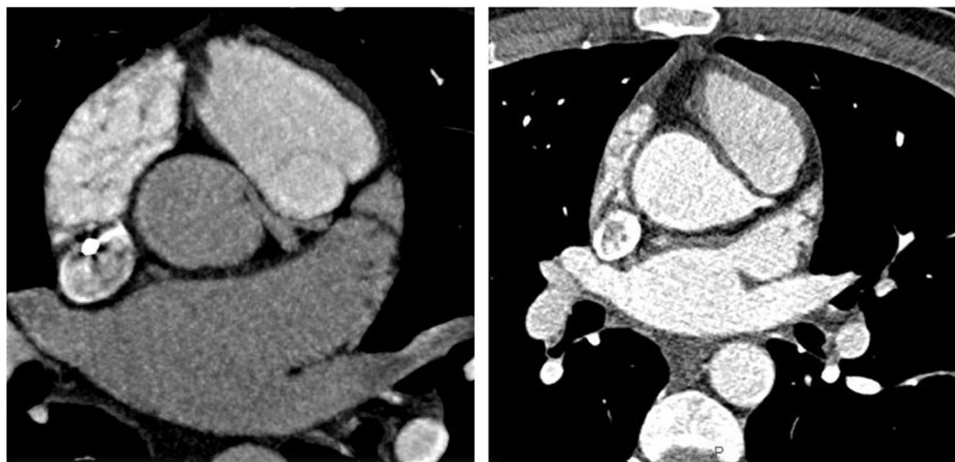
Preoperative and postoperative coronary computed tomography. (Left) Preoperative: the *arrow* indicates the left coronary artery arising from the right aortic sinus and coursing between the aorta and the pulmonary artery. (Right) Postoperative: after “anatomical” repair, a new left coronary ostium is created in the appropriate sinus with a normal angle of take-off and a complete disappearance of the interarterial abnormal course.
